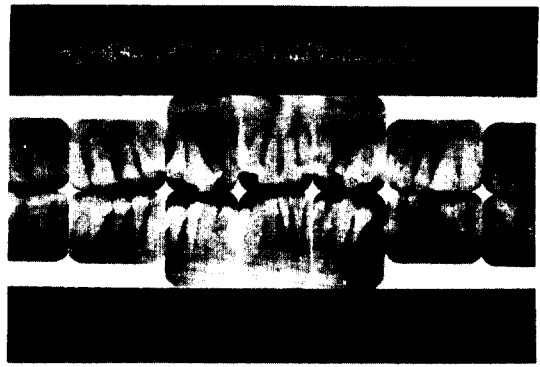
Periapical radiograph at 4 months after tumor resection. Note the newly formed alveolar lamina dura and new bone formation.
